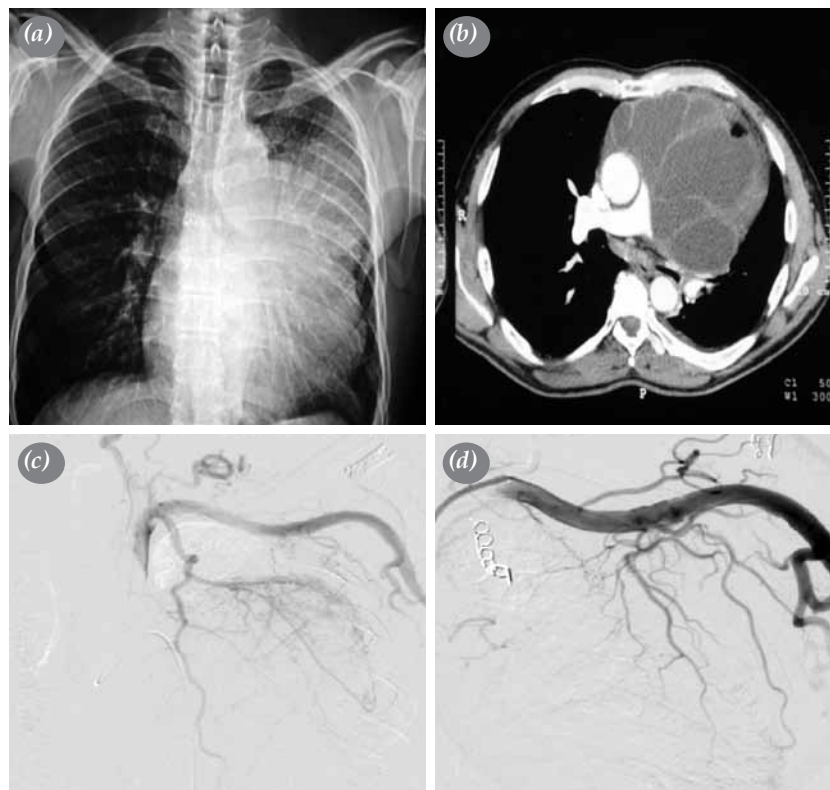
(a) A posteroanterior chest X-ray showing a left mid-upper zone mass. (b) A contrast-enhanced computed tomography scan showing multi-septated heterogeneous mediastinal mass occupying the anterior mediastinal space and extending to left anterolateral region. (c) Digital subtraction angiography showing multiple tortuous feeding arteries originating from left subclavian artery. (d) After coil and particle embolization of the main feeding arteries, minor feeding arteries became more prominent.
